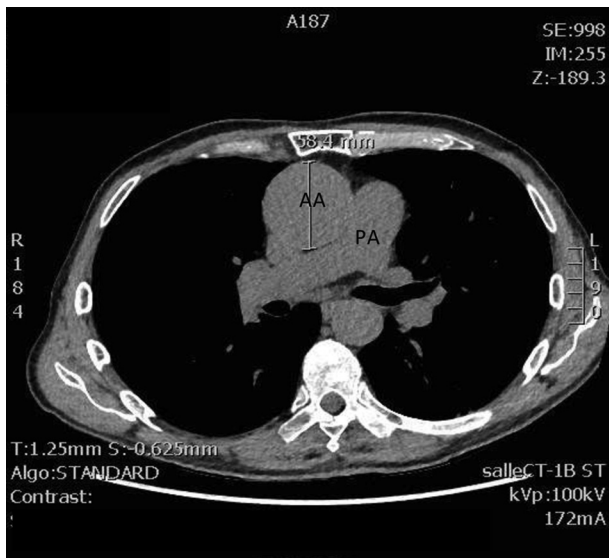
Chest computed tomography showing the AA aneurysm. PA, Pulmonary artery.
